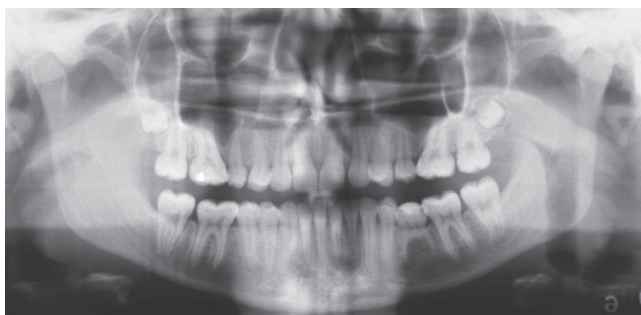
Posttreatment panoramic radiograph of the patient presented in Figure 1.51.
